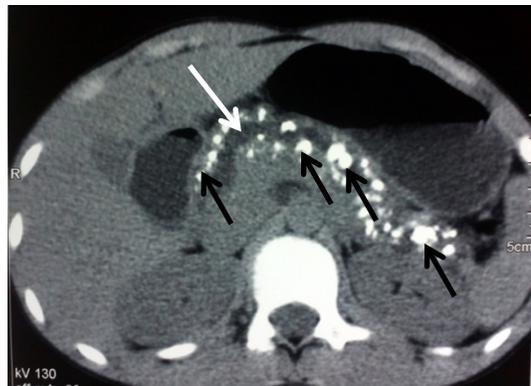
CT of the abdomen showing diffuse pancreatic calcification (black arrows) and dilated pancreatic duct (white arrow).
